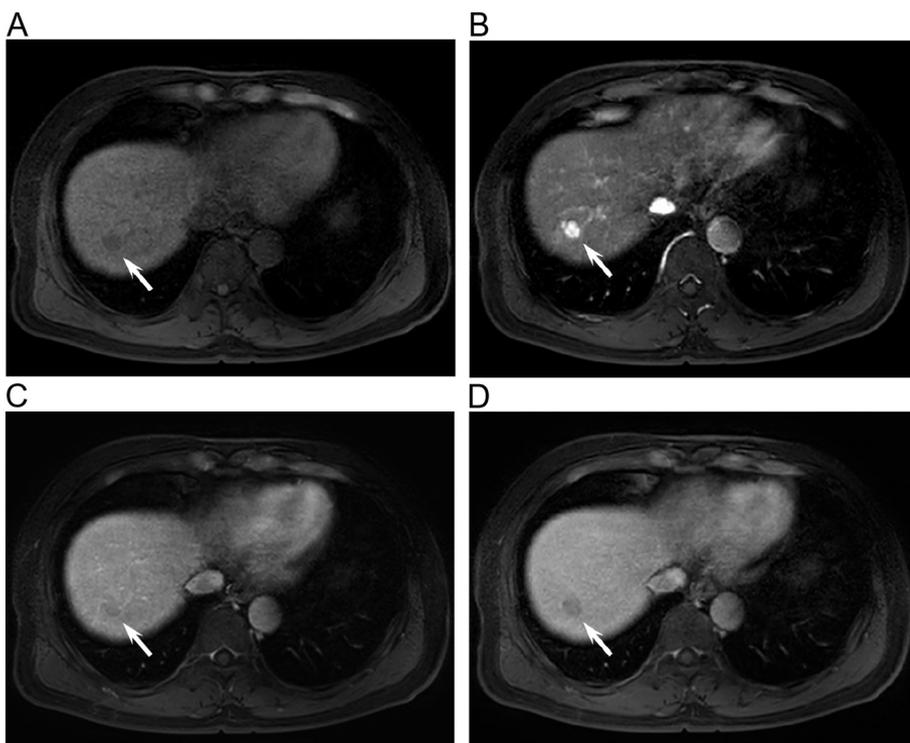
A 55-year-old male with chronic hepatitis C post direct-acting antiviral therapy. Gadoxetic acid-enhanced dynamic MR imaging with CS-eTHRIVE (A, pre-contrast; B, hepatic arterial phase; C, portal venous phase; D, transitional phase) demonstrated excellent image quality without motion artifacts (overall image quality score of 5). A hypervascular hepatocellular nodule was noted in segment VII (arrow).
